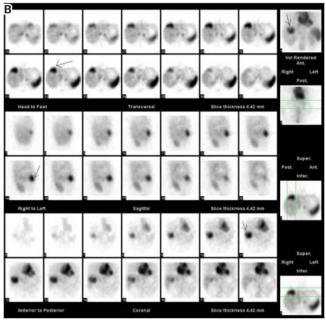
Tc-99m RBC scintigraphy on anterior projection. A) Early phase dynamic (upper row), reframed dynamic (a) and blood-pool images (b) (lower row). B) Late phase SPECT images (transverse, sagittal and coronal slices).
